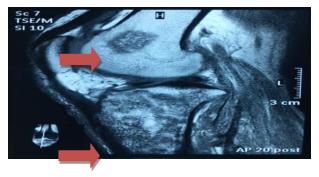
MRI right knee joint showing diffuse altered marrow signal intensity in tibia and patchy areas of altered signal intensity in lower femur suggesting osteomyelitis with bony infarcts.
